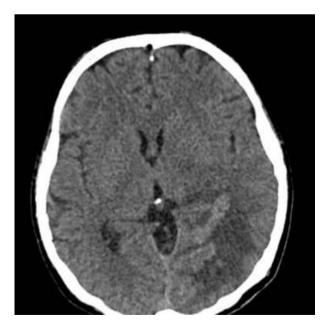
Contrast enhanced CT scan of brain showing hypodense mass lesion involving left posterior parietal, temporal and occipital regions with multiple haemorrhagic foci and perilesional oedema
